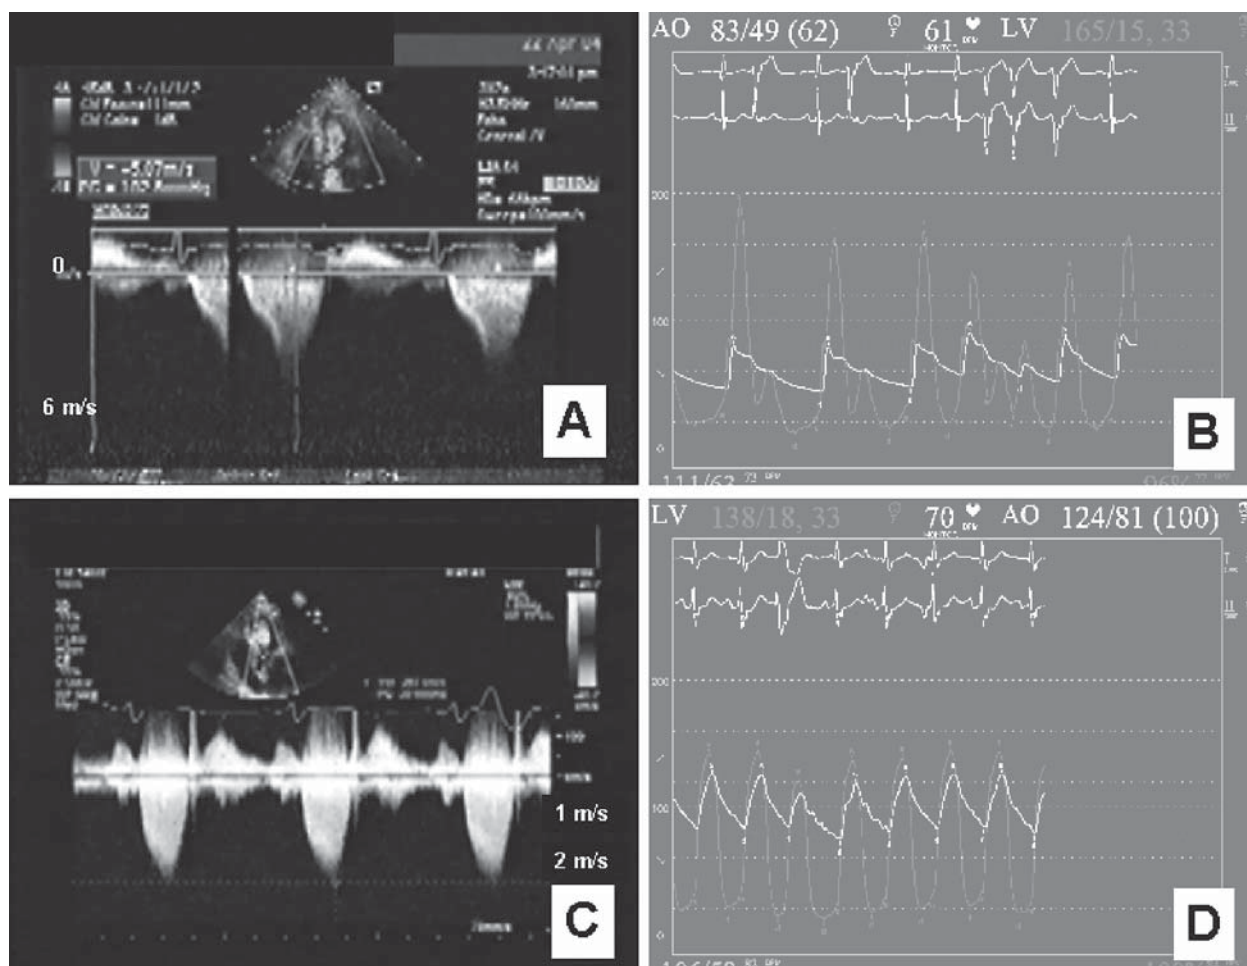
Assessment of left ventricular outflow gradient of patient 2 with hypertrophic cardiomyopathy before (A, B) and after (C, D) alcohol septal ablation using Doppler echocardiography (A, C) and cardiac catheterization (B, D). Significant improvement of the gradient is noted. Left ventricular pressure tracing in grey colour and aortic pressure tracing in white.
